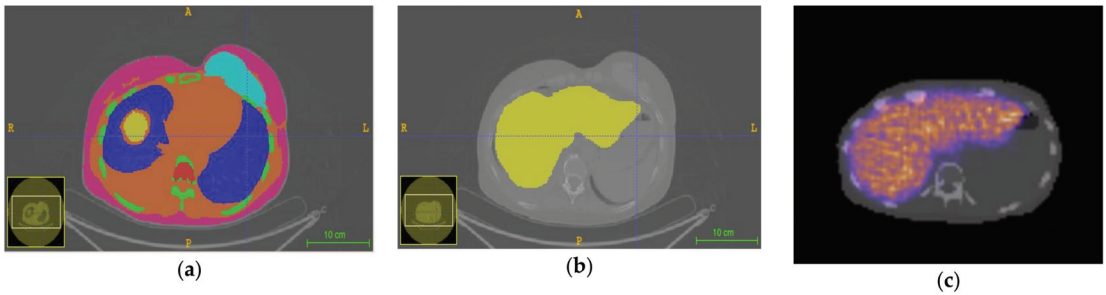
Three transverse slices of different images used in the UL case: (a) contoured CT (in this slice all the contoured regions are visible), (b) activity map, and (c) SPECT superimposed on the coregistered CT.
